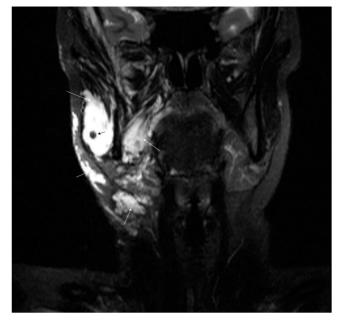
Coronal STIR (short tau inversion recovery) MRI showing a multifocal low-flow vascular malformation in the right side of neck involving the skin and several different spaces (white arrows) with a small plebolith (black arrow) within the masseteric component.
